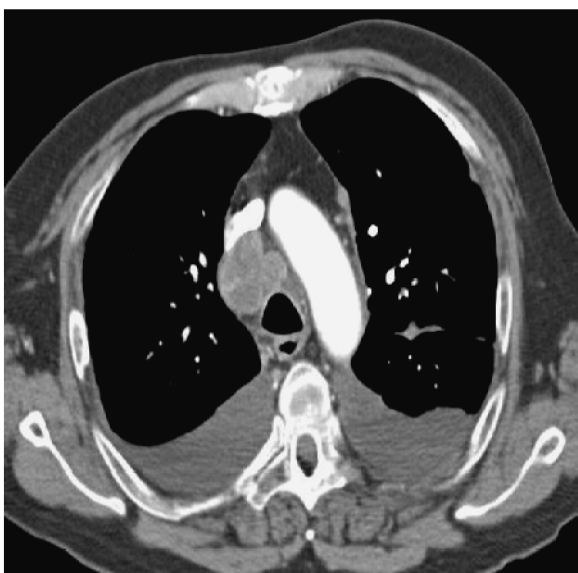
Chest CT with contrast showing large right paratracheal lymph node.
